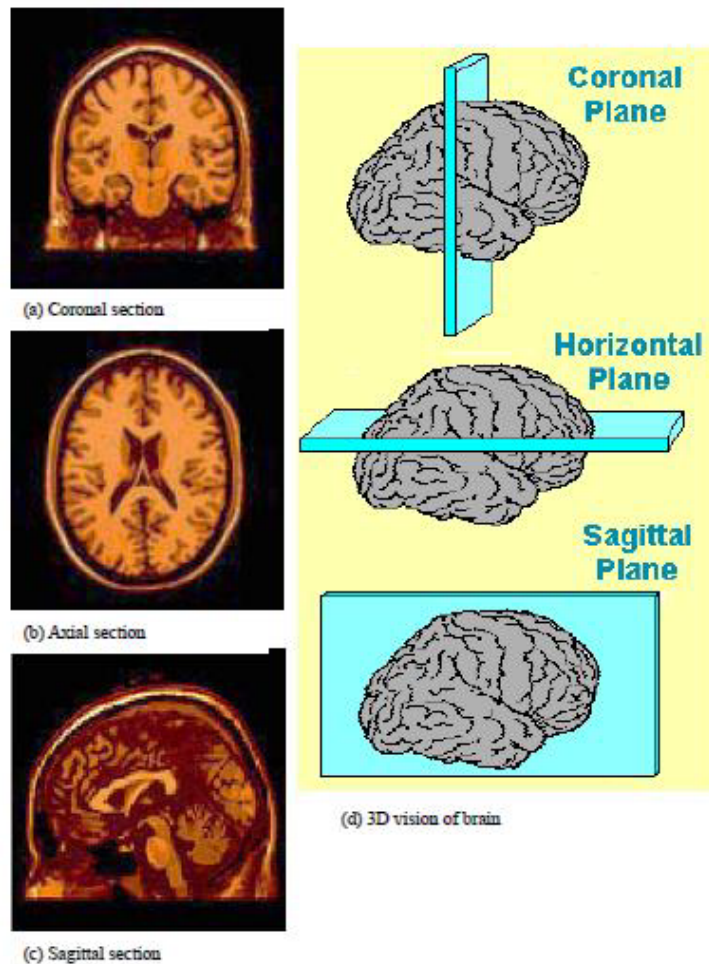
Orthogonal planes used for MR image acquisition
